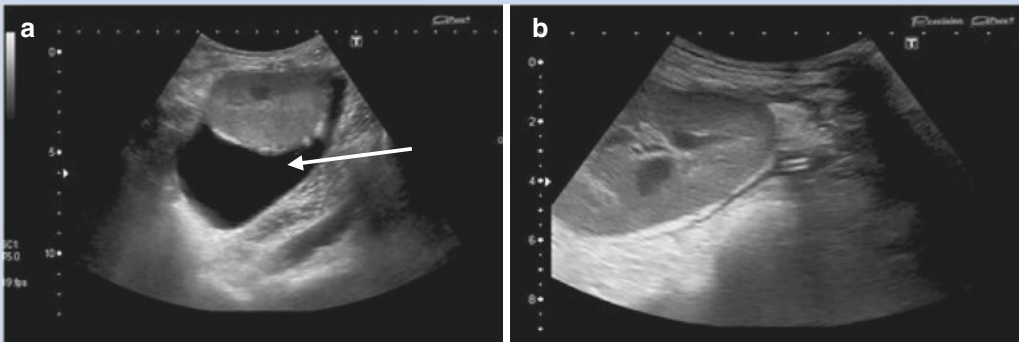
Image shows a kidney transplant ultrasound scan, demonstrating a large peri-transplant collection (a, white arrow), which resolves post drainage (b):
